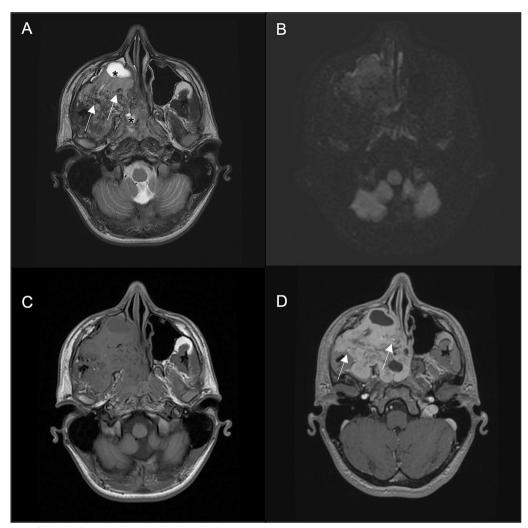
MR imaging findings of juvenile nasopharyngeal angiofibroma (JNA) in a 16-year-old male with nasal obstruction and recurrent epistaxis from the right nostril and vision impairment from the right eye. At axial T2-weighted images (A) JNA shows intermediate-to-high heterogeneous signal with serpentine flow voids (arrows) and degenerative cystic components (asterisks). At axial DWI (B), JNA does not present a high signal. At axial non-contrast T1-weighted images (C), JNA is predominantly isointense, with intense and heterogeneous enhancement after contrast injection (D). Note that some small intratumoral vessels are evidenced after contrast injection (arrow in D)
